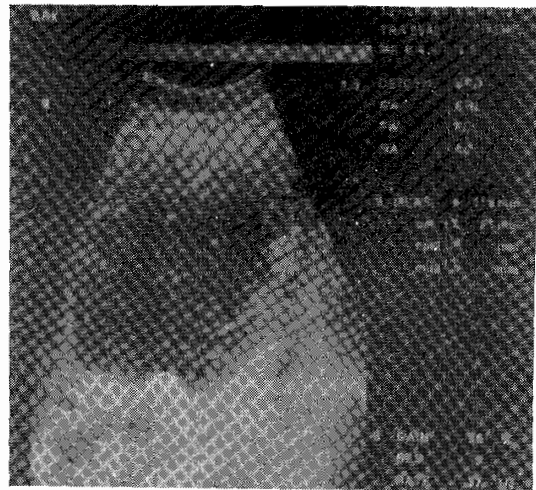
Abdominal ultrasound showing a huge mass on the right side of the uterus.
